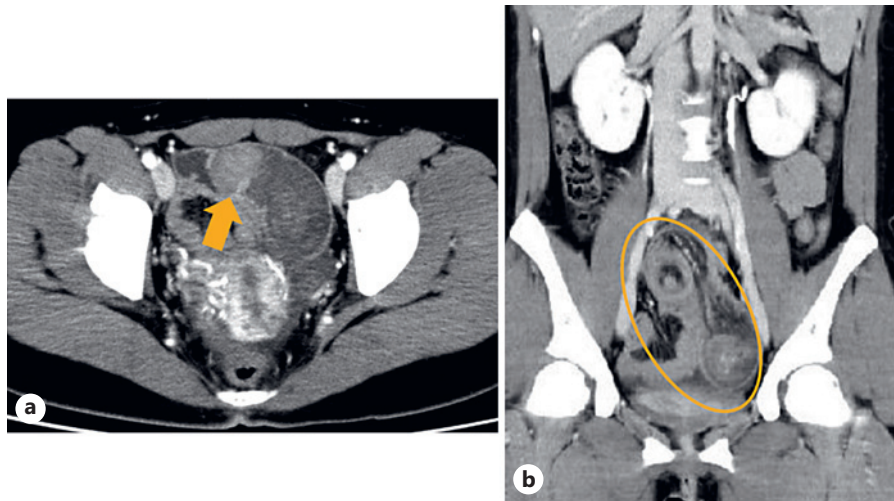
Abdominal enhanced computed tomography imaging. a Tumor in the small intestine (pelvic area) (arrow). b Intussusception with the tumor as the lead point (circle).
